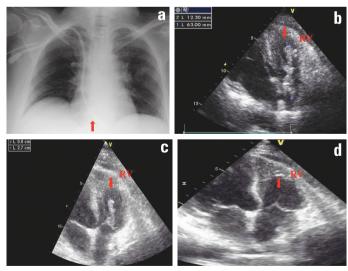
(a) Chest X-ray showing the catheter (arrow) extending to the right ventricle. (b) Transthoracic echocardiographic view showing the catheter and the thrombus attached to it (arrow indicates the catheter; RV - right ventricle). (c) Transthoracic echocardiographic view after surgical removal of the catheter demonstrating the thrombus attached to the tricuspid valve (arrow indicates the thrombus; RV - right ventricle, TV - tricuspid valve). (d) Transthoracic echocardiographic view after heparin infusion complete resolution of the thrombus (RV - right ventricle, TV - tricuspid valve)
